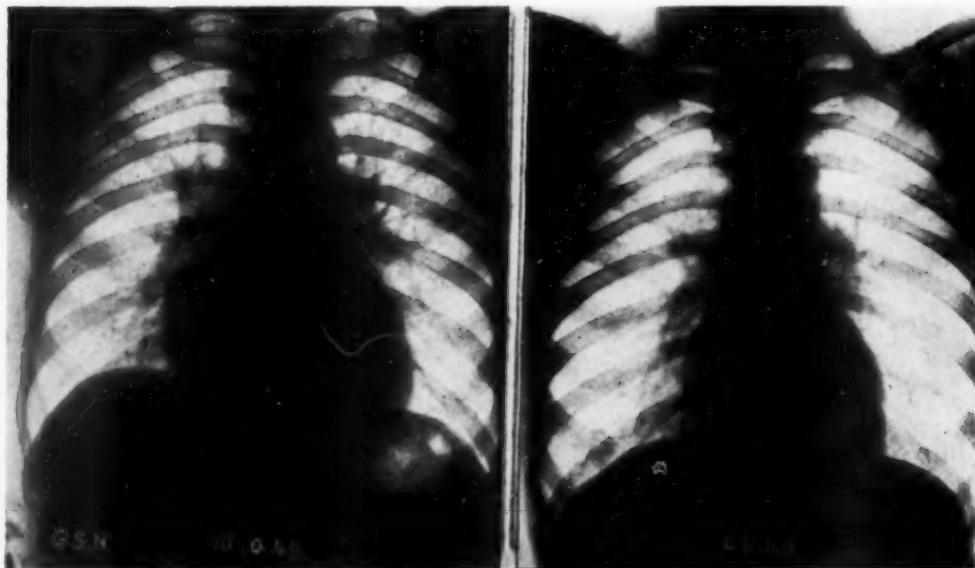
(Case 1).—(G.S.N.)—Roentgenologic signs of predominant right chamber enlargement in addition to hilar congestion, preceding vitamin administration. Notwithstanding the fact that the patient did not submit to bed rest or salt restriction, there was a marked decrease in heart size after three weeks of thiamine treatment.
